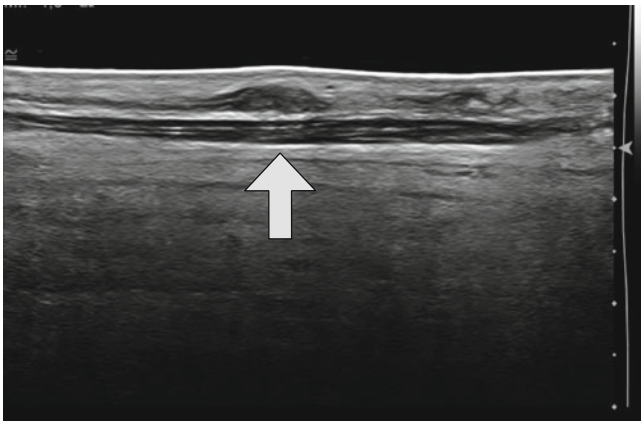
Sural neuroma. The patient had a nerve biopsy and several years later developed pain and allodynia in his foot. There was a pronounced Tinel's sign in the area of the scar. Ultrasound showed the neuroma (arrow)
